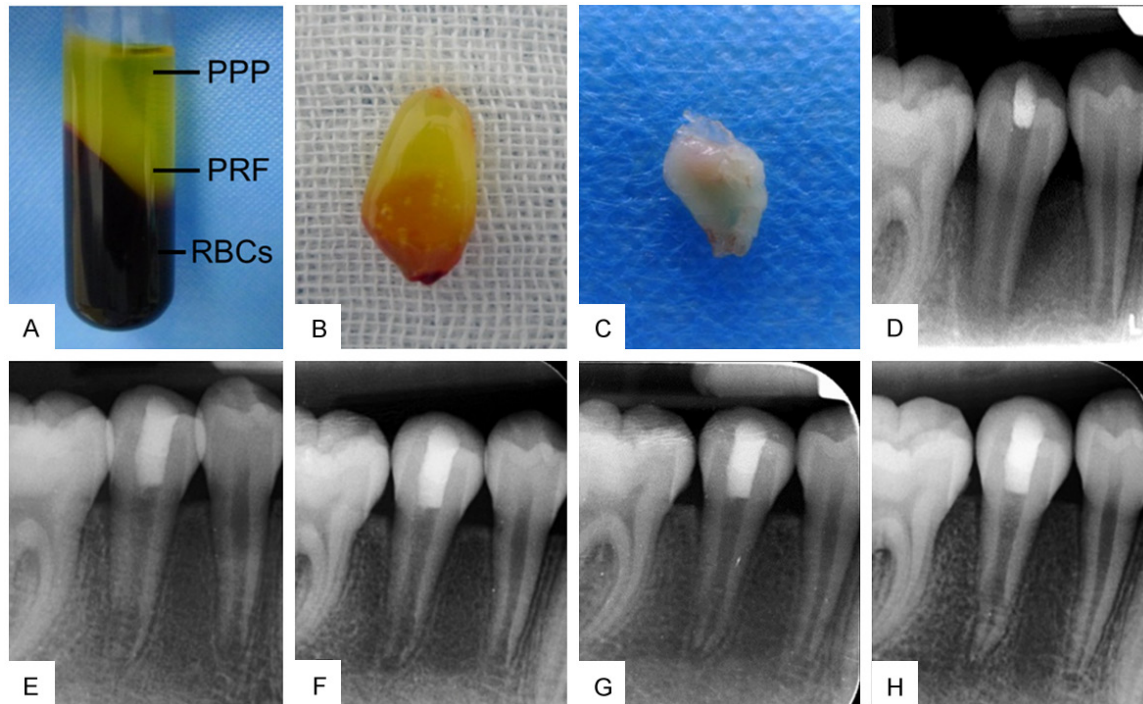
PRF preparation and periapical radiographs in case 1. A. 3 layers obtained after centrifugation: platelet-poor plasma at the top, platelet-rich fibrin in the middle, and red blood cells at the bottom. B. Platelet-rich fibrin clot on sterile dry gauze. C. Platelet-rich fibrin membrane. D. Preoperative intraoral periapical radiograph of tooth #29 showing an incomplete apex with a periradicular radiolucency. E. A 3-month follow-up radiograph showing that the periapical radiolucency healed completely, and the root elongated. F. The 6-month follow-up radiograph showing continued root development. G. The 9-month follow-up radiograph showing continued root development and the narrowing of the apical foramen. H. The 12-month follow-up radiograph showing complete root development and closure of the root apex.
